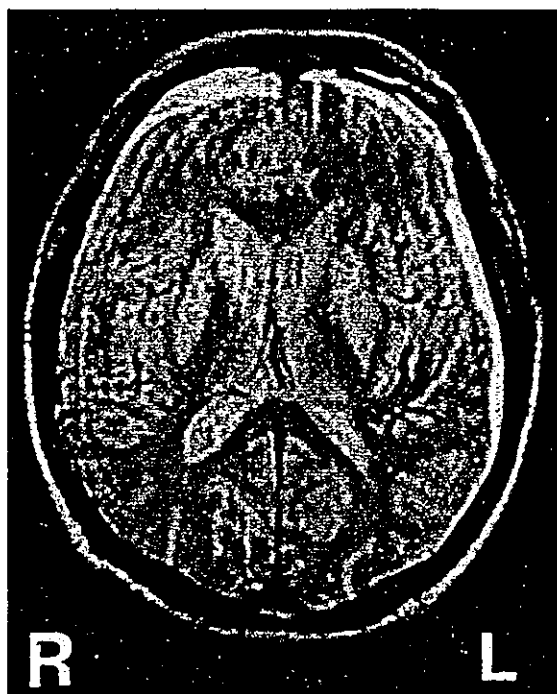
Cranial MRI on admission showing bilateral hyperintensity in the caudate nuclei and putamina on T2-weighted sequences (TR 3,500 ms, TE 19 ms).
